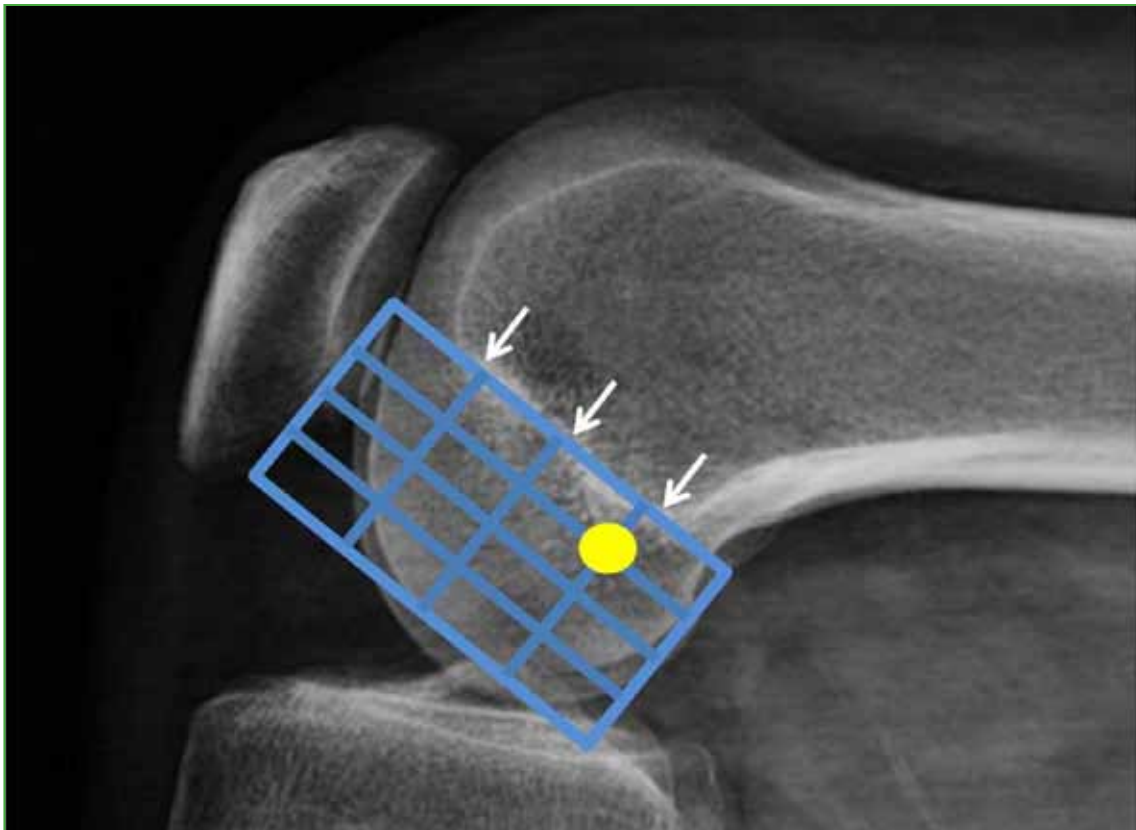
Quadrant method. Lateral X-ray with 90° flexion: Blumensaat's line and the borders of the femoral condyles are used as reference, dividing each side of the square into four parts. The optimal location of the femoral tunnel is located in the anteroinferior corner of the posterosuperior quadrant.
